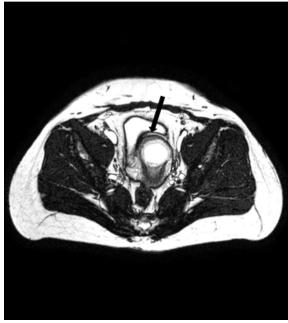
Axial Balanced Turbo Field Echo (BTFE) MRI images at level of caesarean scar showed a thin layer of myometrium separating the gestational sac from the urinary bladder (black arrow).
